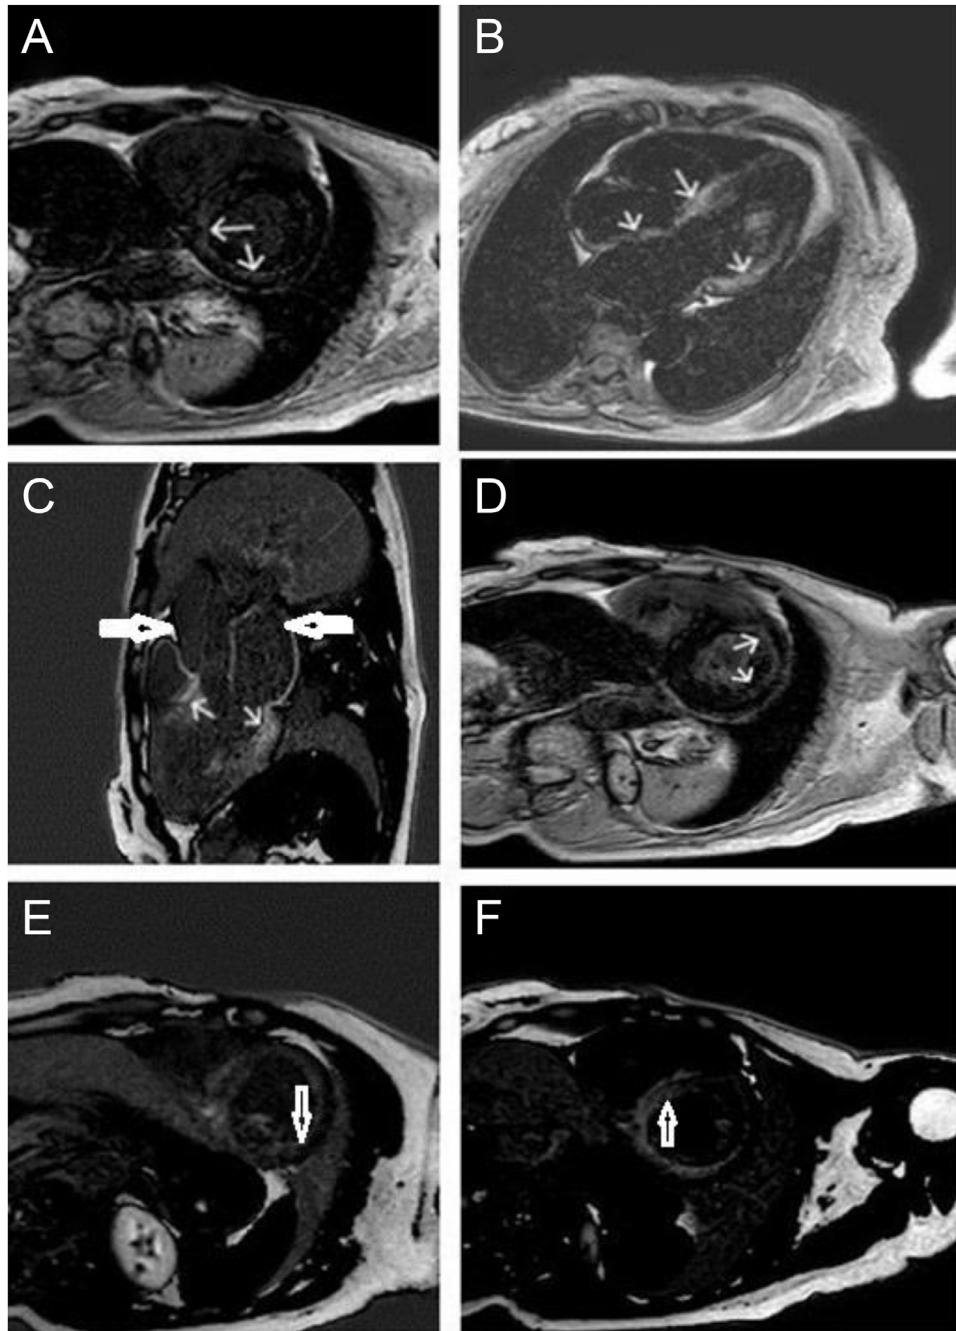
LGE MR image (3 -chamber LV out flow (C), short axis views (A, D) and 4-chamber view (B) show patchy late gadolinium enhancement at the base relative to the apex of the myocardium, highlighting the base-to-apex gradient (arrows). In addition, there is diffuse enhancement of both atrial wall (C large arrows). In many parts. the enhancement is subendocardial, most pronounced on (E) short axis subendocardial pattern enhancement at apical lateral wall, (F) short axis view small focal transmural pattern and additional areas of subendocardial enhancement of mid anteroseptal and inferoseptal wall.
